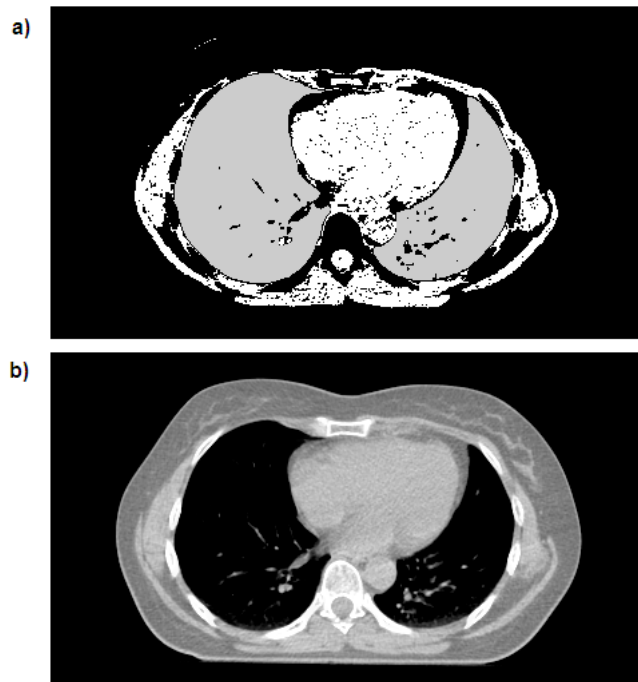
a) The result of region growing from a seed placed in the lungs (shown in grey) and in the heart (shown in white). Due to the similarity of the appearance of the heart and the adjacent chest-wall, the region has spread beyond the heart, into the chest-wall and other surrounding structures. b) The original CT slice.
